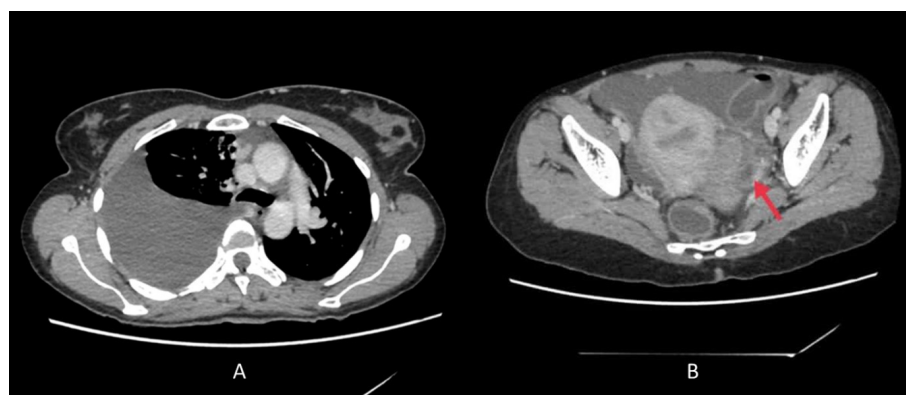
CT Thorax showing right sided pleural effusion. 5B: CT abdomen showing left ovarian lesion and an adnexal mass on left side (Red arrow).
